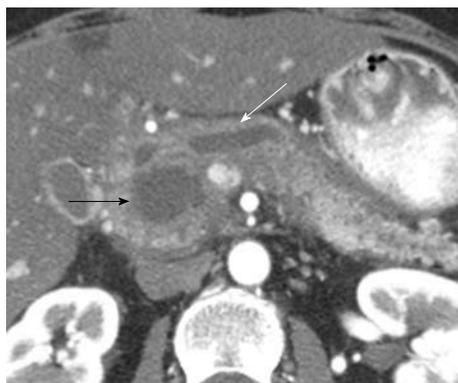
A 49-year-old woman with a history of epigastric and lower abdominal pain accompanied by abnormal liver function studies. Axial contrast-enhanced computed tomography scan of the abdomen shows cystic change (black arrow) within the pancreas with associated biliary ductal dilation (white arrow). When correlated with the patient's history and endoscopic ultrasound with FNA findings, this was consistent with a pseudocyst.
